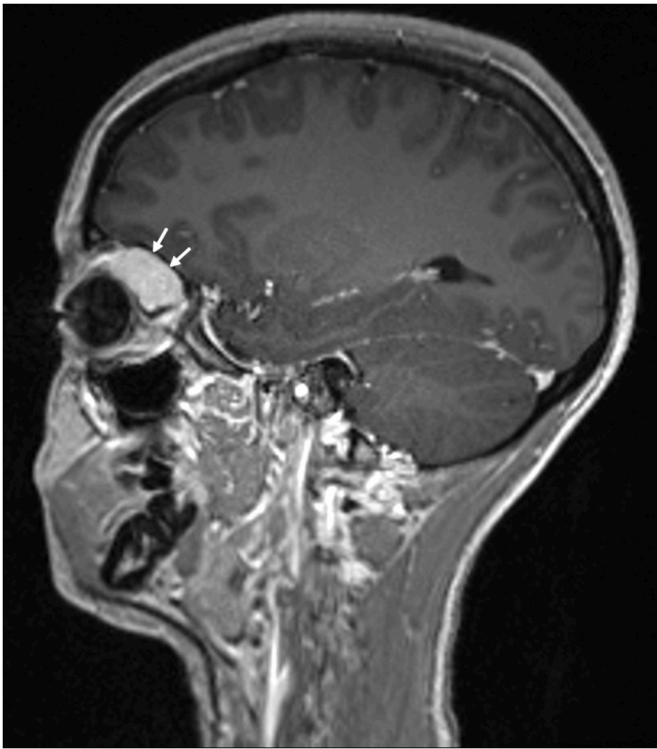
Sagittal T1-weighted post-contrast magnetic resonance image (MR) showing an orbital mass involving the left orbit, denoted by white arrows.
